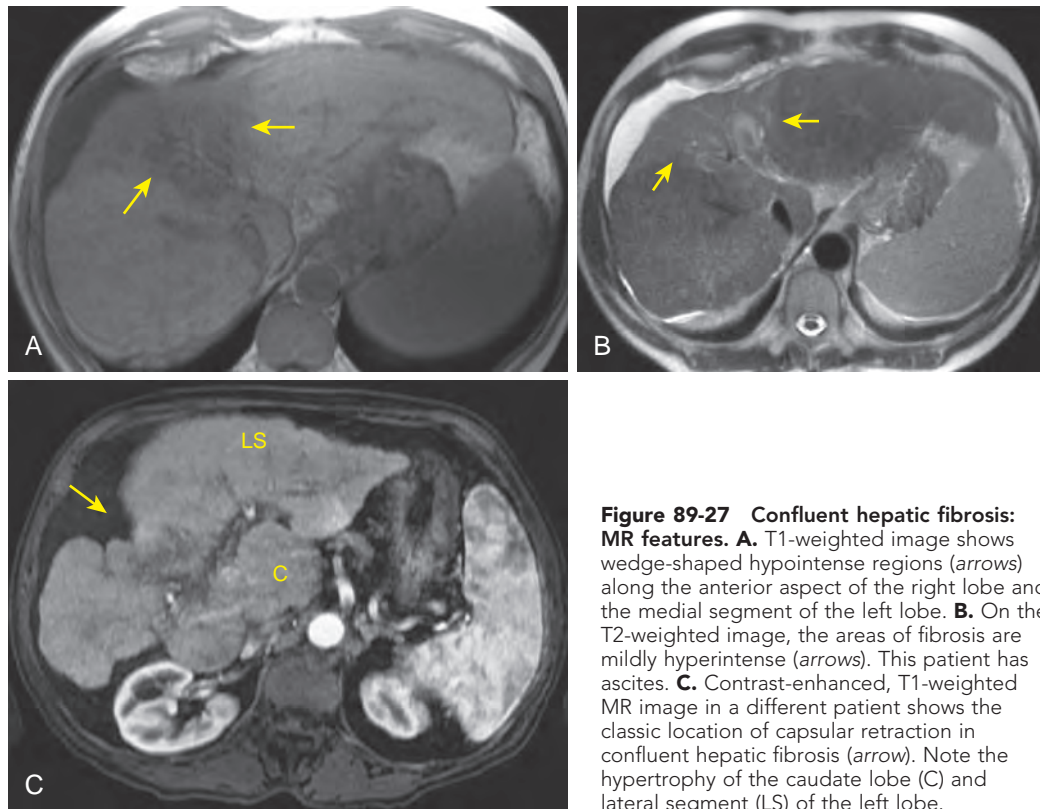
Confluent hepatic fibrosis: MR features. A. T1-weighted image shows wedge-shaped hypointense regions (arrows) along the anterior aspect of the right lobe and the medial segment of the left lobe. B. On the T2-weighted image, the areas of fibrosis are mildly hyperintense (arrows). This patient has ascites. C. Contrast-enhanced, T1-weighted MR image in a different patient shows the classic location of capsular retraction in confluent hepatic fibrosis (arrow). Note the hypertrophy of the caudate lobe (C) and lateral segment (LS) of the left lobe.
